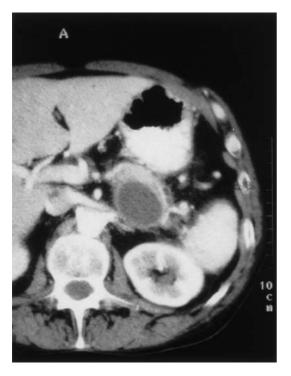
Follow-up CT scan at 8 weeks shows no evidence of recanalisation. The lumen remains occluded. Note the reduction in the size of the pseudoaneurysmal sac from 5.0 to 3.8 cm
